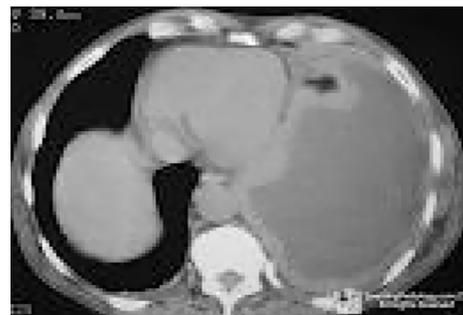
CT showing massive effusion and circumferential pleural thickening.
